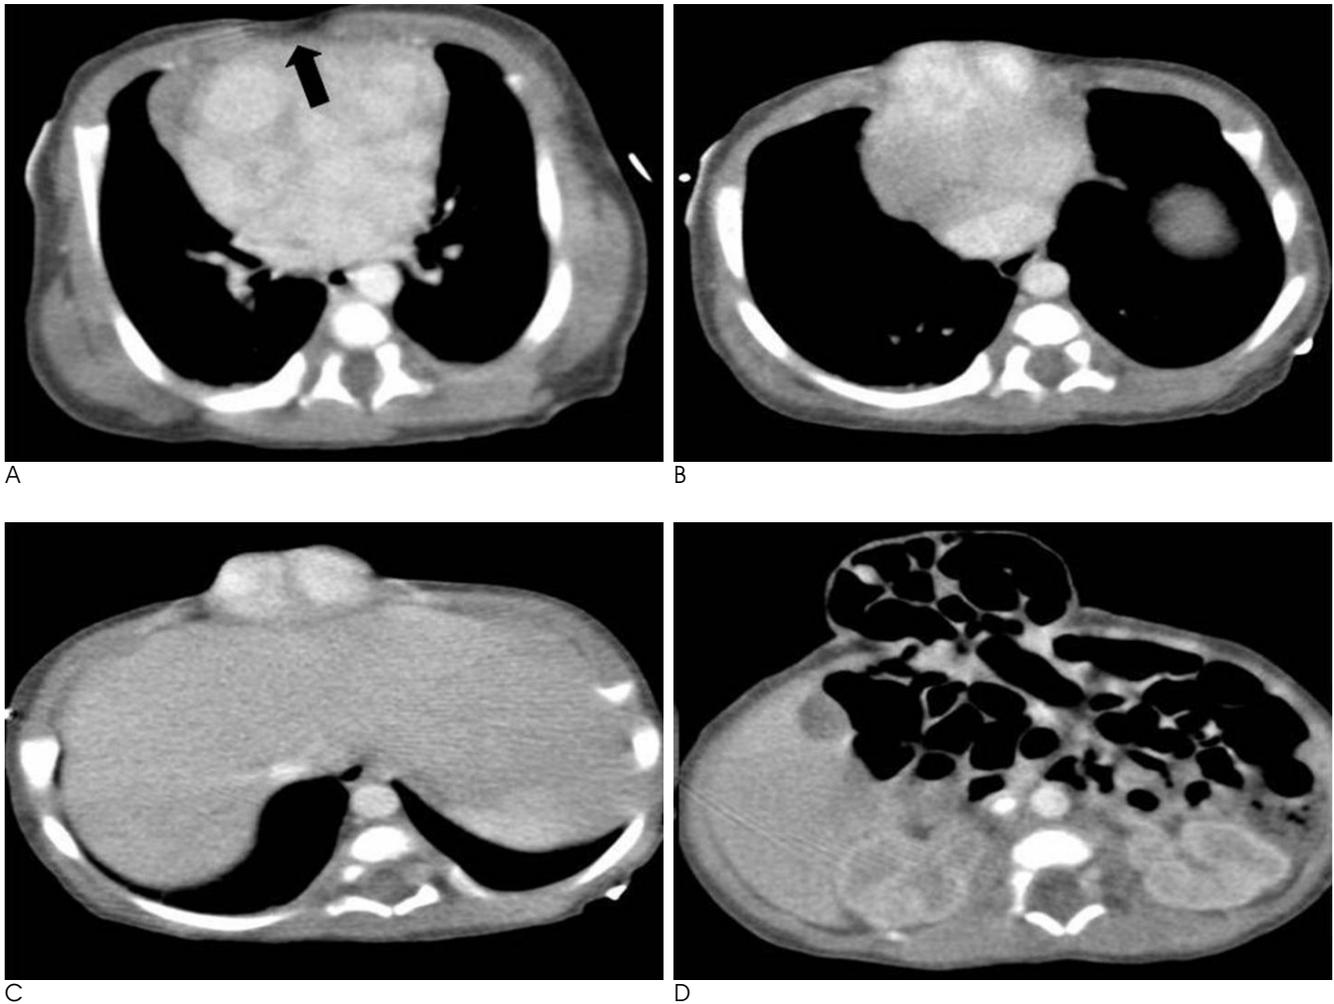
The contrast-enhanced axial CT shows a defect of the inferior sternum (arrow) (A), anterior diaphragm, and anterior abdominal wall with ectopia cordis (B, C) and an omphalocele (D).
